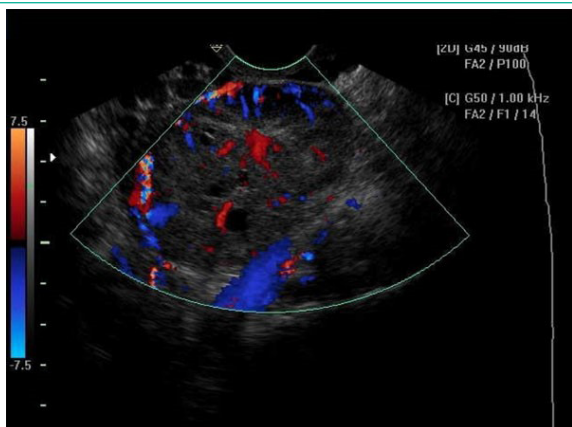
TVUS: solid tumor of the right ovary with high color content at color Doppler.
